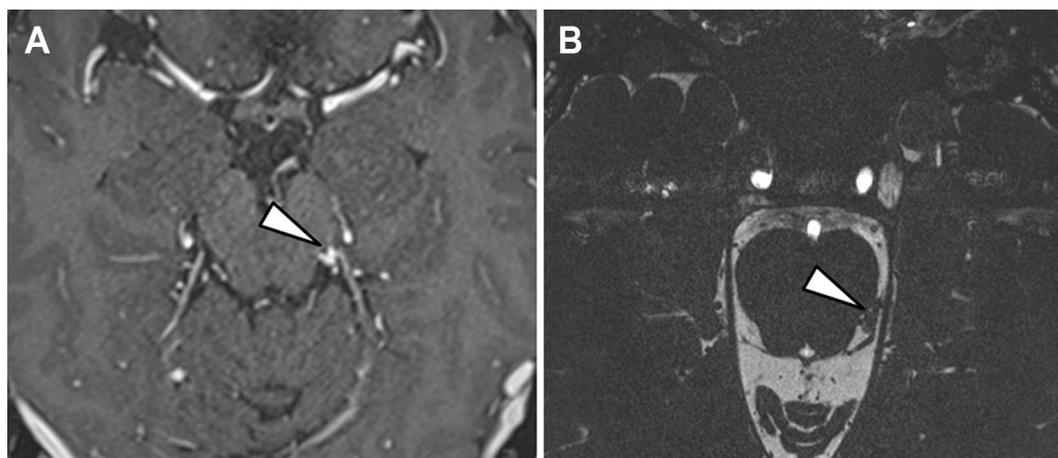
A 50-year-old male patient with left fourth nerve palsy. Axial 3D-MPRAGE image (A) and 3D-CISS image (B) demonstrate nodular enhancement, suggestive of schwannoma (arrowheads). The size of the enhancing mass did not change on repeated magnetic resonance imaging during two years of follow-up.
